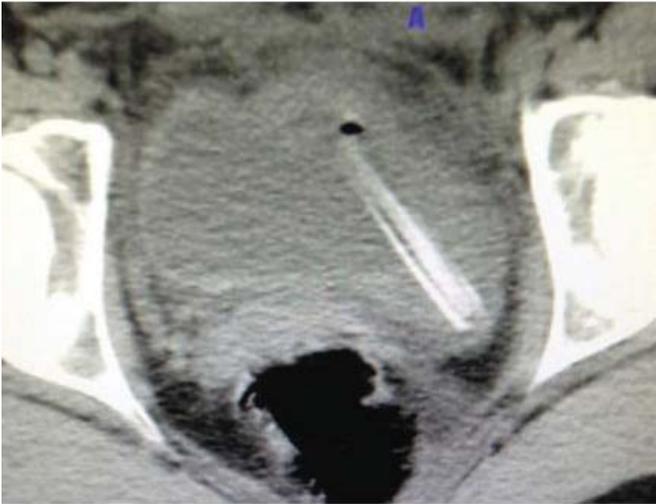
A foreign body with linear elongation is seen in the MRI.
